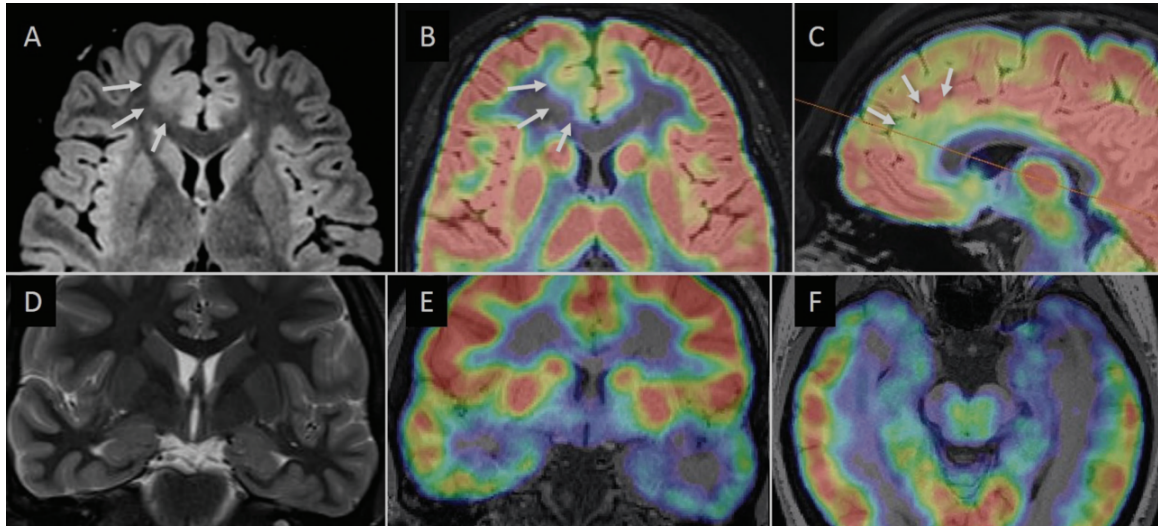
Co-registration of MRI and PET. Localization of an FCD is showcased by the arrows in different anatomical views. Adapted from (41).
